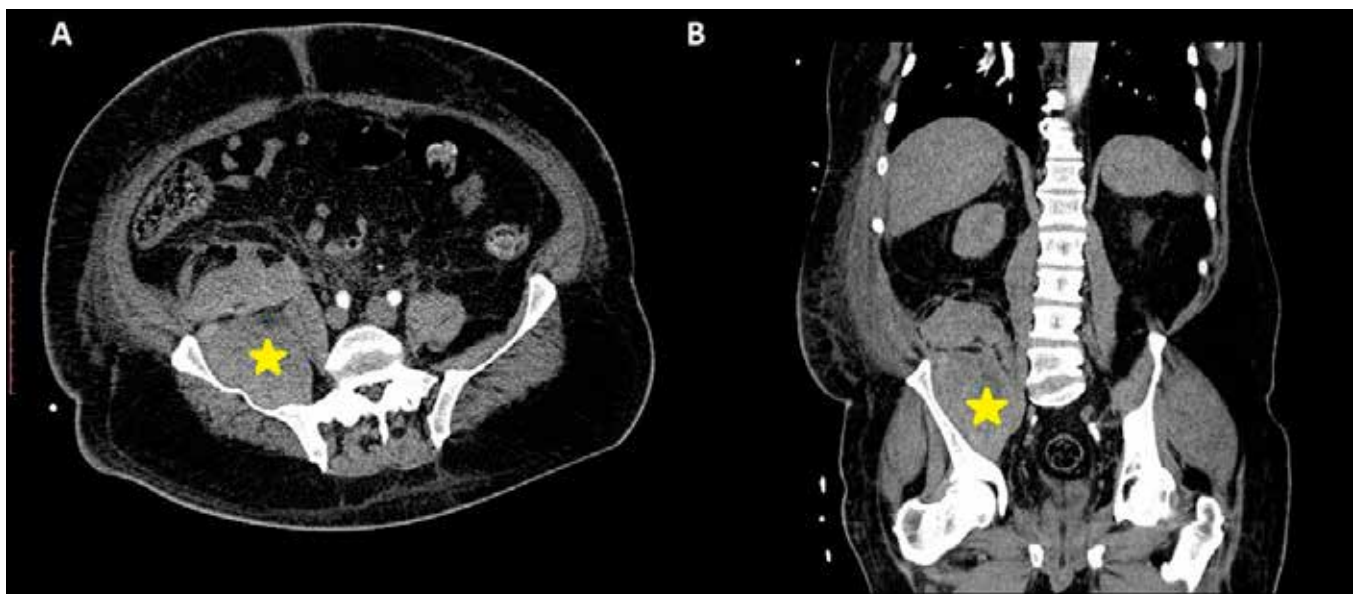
A CT scan of the abdomen and pelvis (transverse section [A], coronal section [B]); showing retroperitoneal haematoma, marked with a yellow star
